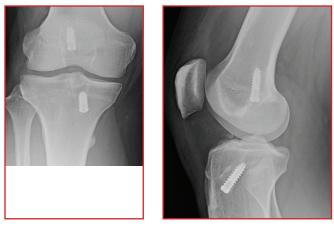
AP and lateral radiographs of right knee demonstrating previous autograft bone-patellar tendon-bone (BTB) ACL reconstruction with vertical graft placement.
